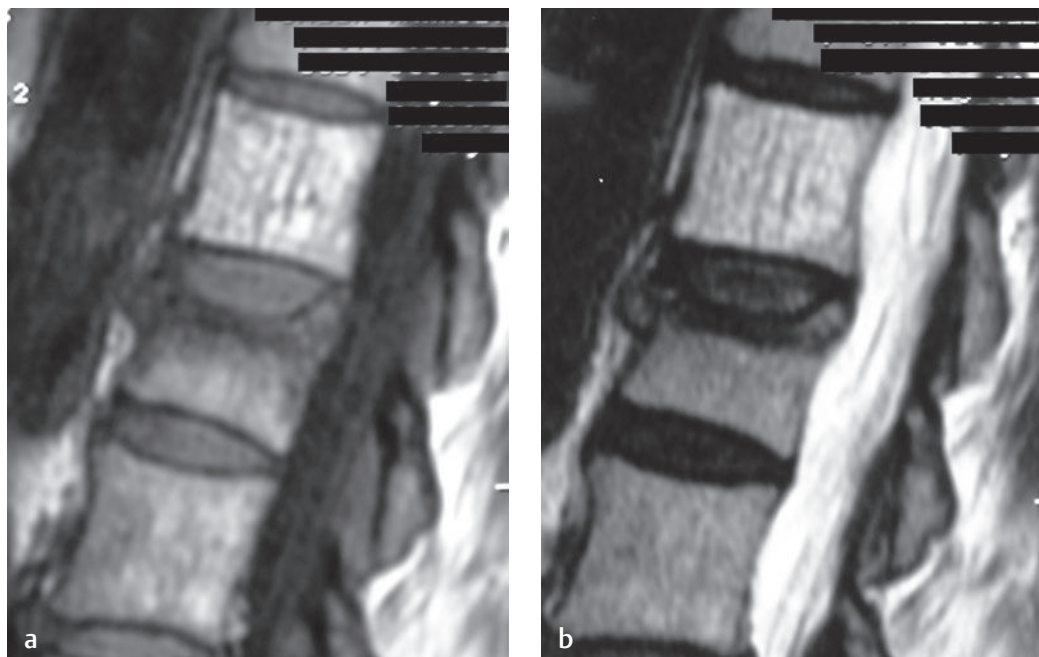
These sagittal (a) T1-weighted and (b) T2-weighted images show a lesion at the T12 level with high signal intensity on both images and with the typical striations compatible with a vertebral body hemangioma. An incidentally noted vertebral compression fracture is seen at the L1 level.[†]
